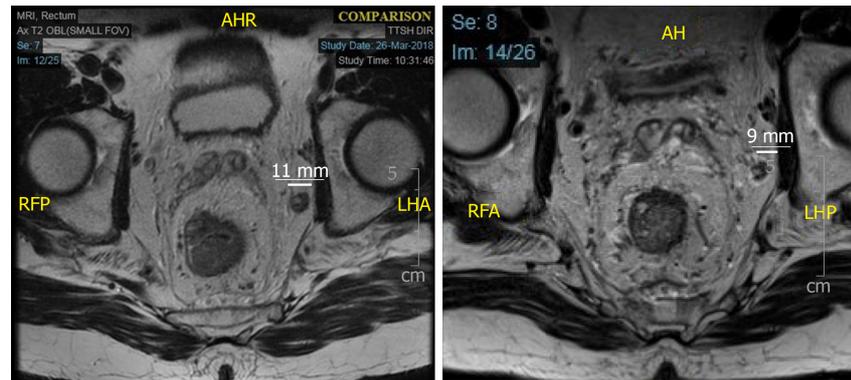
Magnetic resonance imaging rectum showing an enlarged, metastatic, left internal iliac node before (left, 11 mm) and after (right, 9 mm) neoadjuvant chemoradiation.
